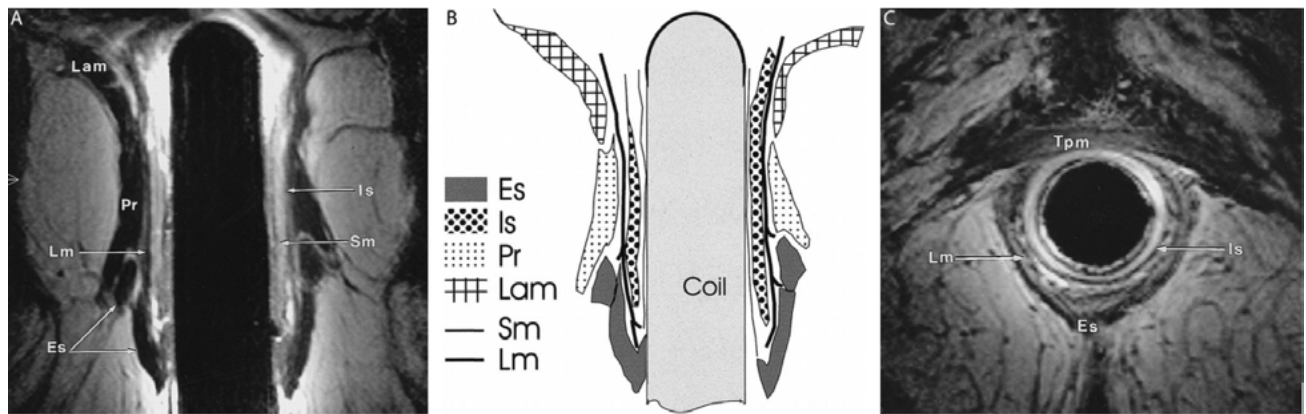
T2-weighted turbo spin-echo endoanal coil MRI studies by Rociu et al (23, 24).
